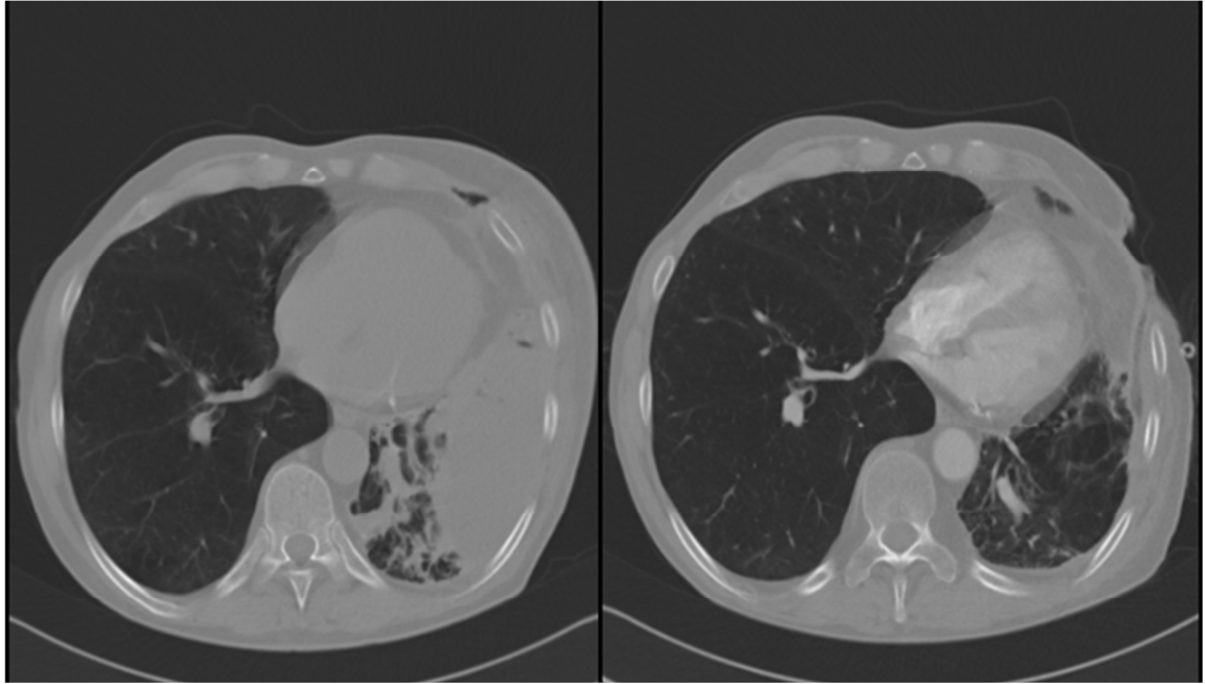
Radiologic demonstration that intrapleural VAC could help expand dystelectatic lung; on the left side is the CT before VAC and on right side is the CT after VAC therapy.
